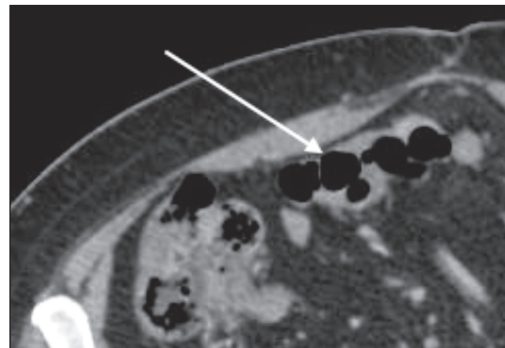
Computed tomography of the abdomen showing multiple rounded air images in redundant sigmoid wall.
